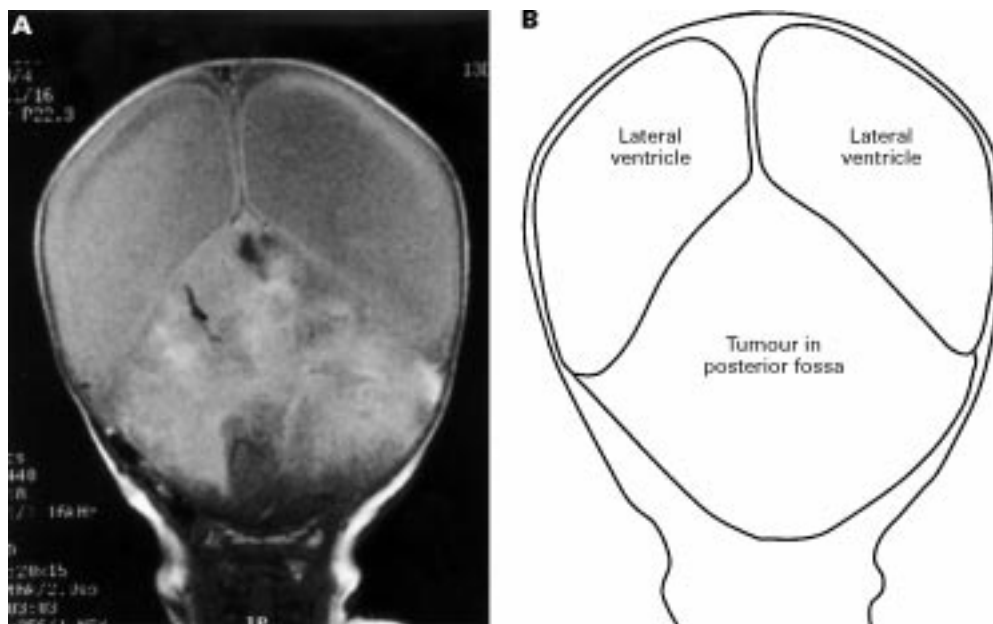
T1 weighted MRI scan (coronal section).
